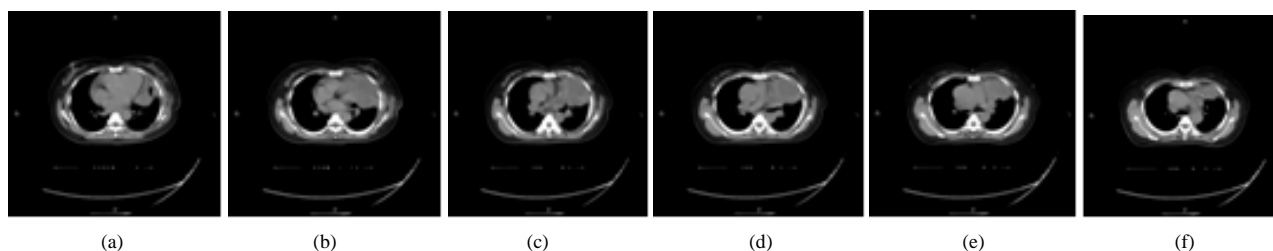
(a) - (f): 2013.09.03 enhanced chest CT. In left mediastinal there is a lumpy, mixed and hypodense foci, with clear boundary, with visible complete capsule, the size of about 9.7 cm \* 7.3 cm. Inside there is fat-like hypodense foci, the CT value about -100 HU, and shows multiple nodular lumps and higher density; its inner and envelope shows multiple calcified spots. Impression: The left mediastinal space occupying, of high possibility of large teratoma
